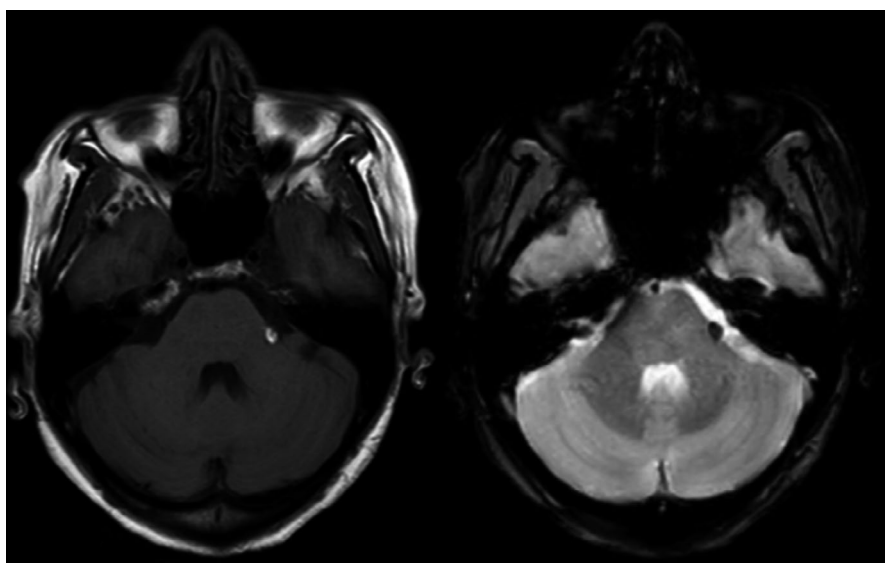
1-year follow-up MRI demonstrating no modification
